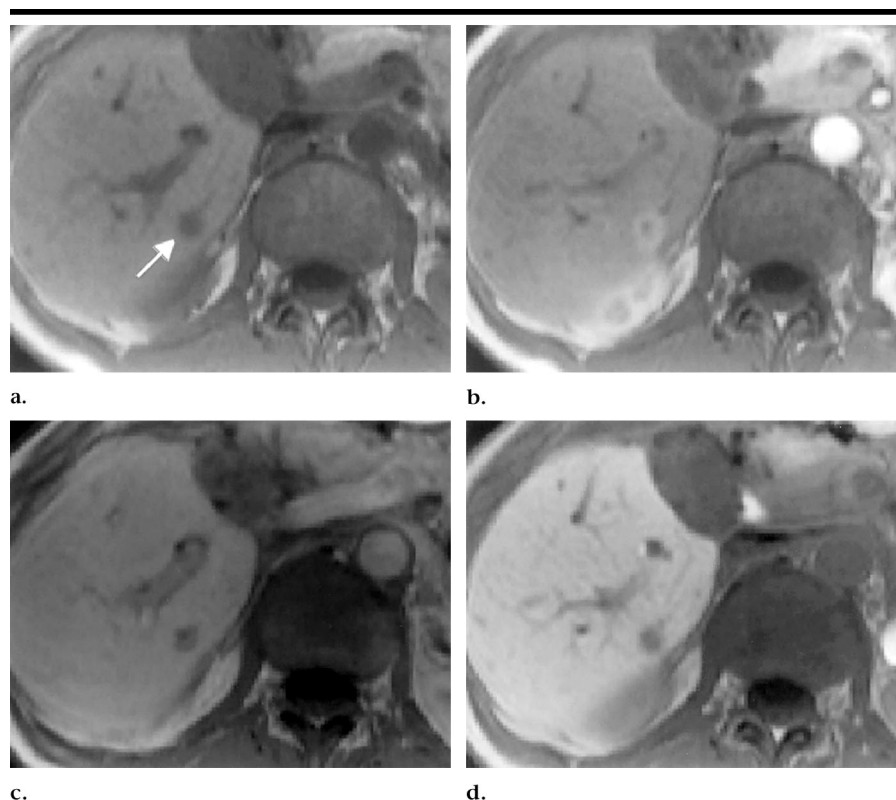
Transverse T1-weighted gradient-echo MR images (141/4.1, 75° flip angle) of the liver obtained at 1.5 T show a hypervascular metastasis from primary gastric leiomyosarcoma in a 61-year-old woman. (a) Nonenhanced image shows a small hypointense lesion (arrow) in segment VI. (b) On an image obtained about 15 seconds after administration of 0.025 mmol/kg of gadoxetic acid (ie, during the arterial phase), the lesion shows high degree of peripheral enhancement, which is characteristic of hypervascular lesions. (c) Image obtained about 60 seconds after contrast agent administration (ie, during the portal venous phase) shows the rapid washout of the contrast agent. (d) On an image obtained 20 minutes after contrast agent injection, the lesion shows no substantial uptake of the liver-specific contrast agent in the delayed phase. These images demonstrate the ability of MR imaging performed with the liver-specific contrast agent gadoxetic acid to yield dynamic information comparable to that provided by MR imaging performed with non-liver-specific extracellular contrast agents.
